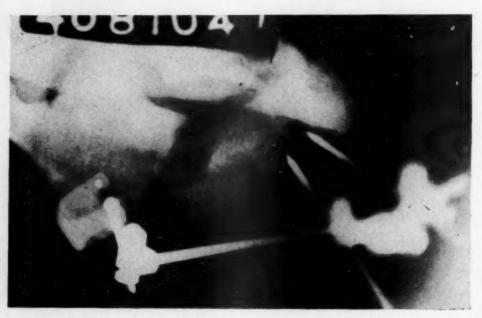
Postoperative x-ray showing clamp attached at the posterior border of the ramus. Pins were inserted in the anterior part of the mandible. Fracture was impacted at the inner plate; some of the outer plate had been destroyed by osteomyelitis.
